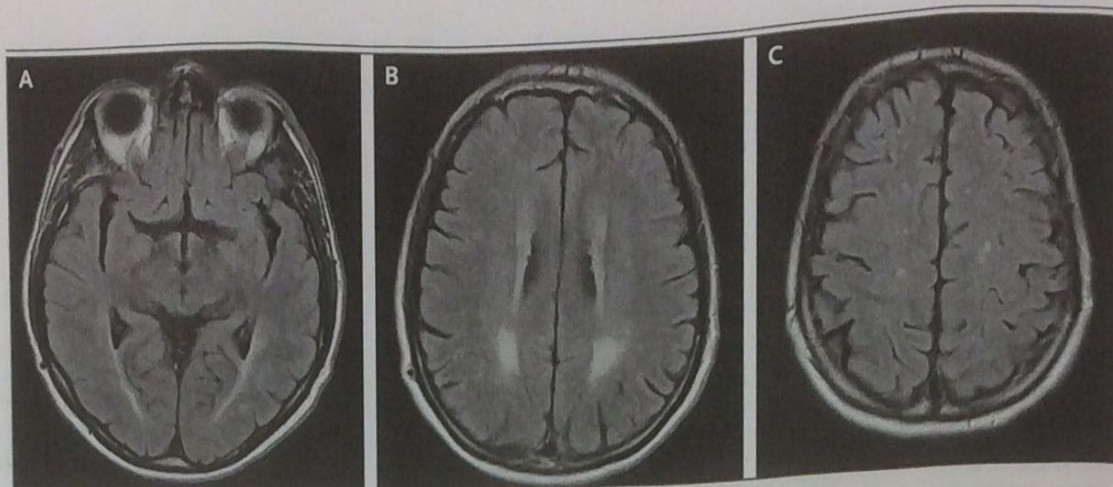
MRI of the Head at the 7-Week Follow-up Examination.
